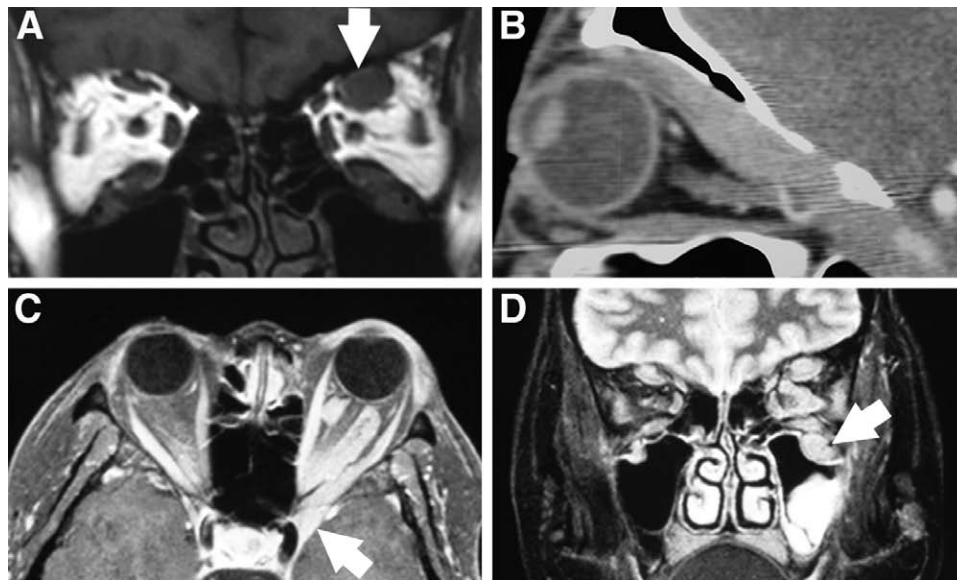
Case 8. Enlarged lacrimal glands and frontal and infraorbital nerves, cervical lymphadenopathy, enlarged parotid glands and submandibular glands, primary biliary cirrhosis, developed left periopic nerve disease, which on rebiopsy was found to be marginal zone lymphoma of mucosal-associated lymphoid tissue type. A, A 52-year-old woman presented in 2008 with a 1 year history of bilateral lacrimal gland enlargement, cervical lymphadenopathy, and salivary gland enlargement. She had a history of primary biliary cirrhosis, and atypical "Sjögren syndrome" with negative serology. MRI scans showed an enlarged left frontal nerve (arrow). B, A sagittal CT scan showed the frontal nerve enlargement extending through the superior orbital fissure into the cavernous sinus. The left lacrimal gland and frontal nerve were biopsied. They showed reactive lymphoid hyperplasia with large numbers of IgG4+ plasma cells, and a ratio of IgG4+/IgG+ plasma cells of 80%, and a markedly elevated serum IgG4 level. She was treated with low dose prednisolone and hydroxychloroquine by her rheumatologist with minimal response. C, Two years later, she developed worsening vision in the left eye and a repeat MRI showed disease surrounding the optic nerve, and also extending through the superior orbital fissure into the cavernous sinus (arrow). D, A coronal MRI showed definite enlargement of the left more than right frontal nerves, and the left infraorbital nerve and canal (arrow). A rebiopsy showed transformation to marginal zone lymphoma of mucosal-associated lymphoid tissue type. She was treated with low dose orbital irradiation with improvement in vision and proptosis and significant reduction in tumor bulk.
